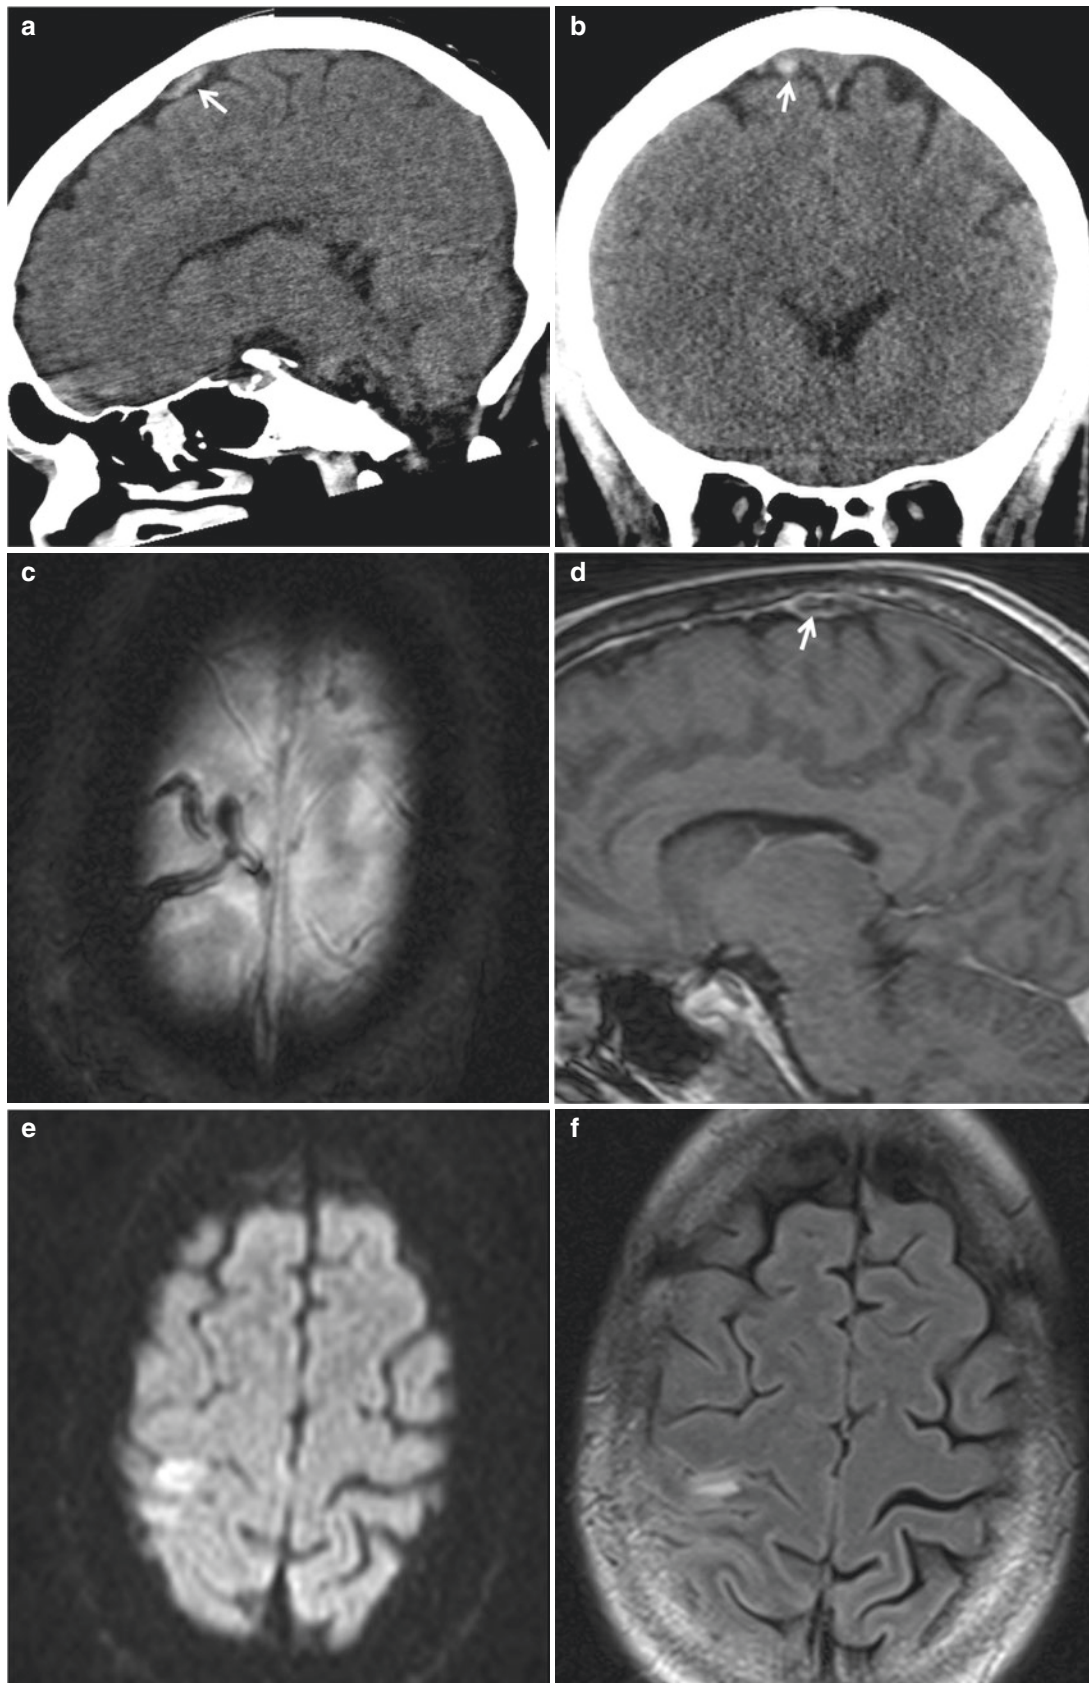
Isolated cortical vein thrombosis. A 54-year-old with history of lymphoma presents with seizure. Sagittal (a) and coronal (b) NCCT images show a cord-like hyperdense structure in the right superior frontal subarachnoid space (arrow). This was initially misinterpreted as sulcal subarachnoid hemorrhage. (c) Axial MRI gradient recall echo
